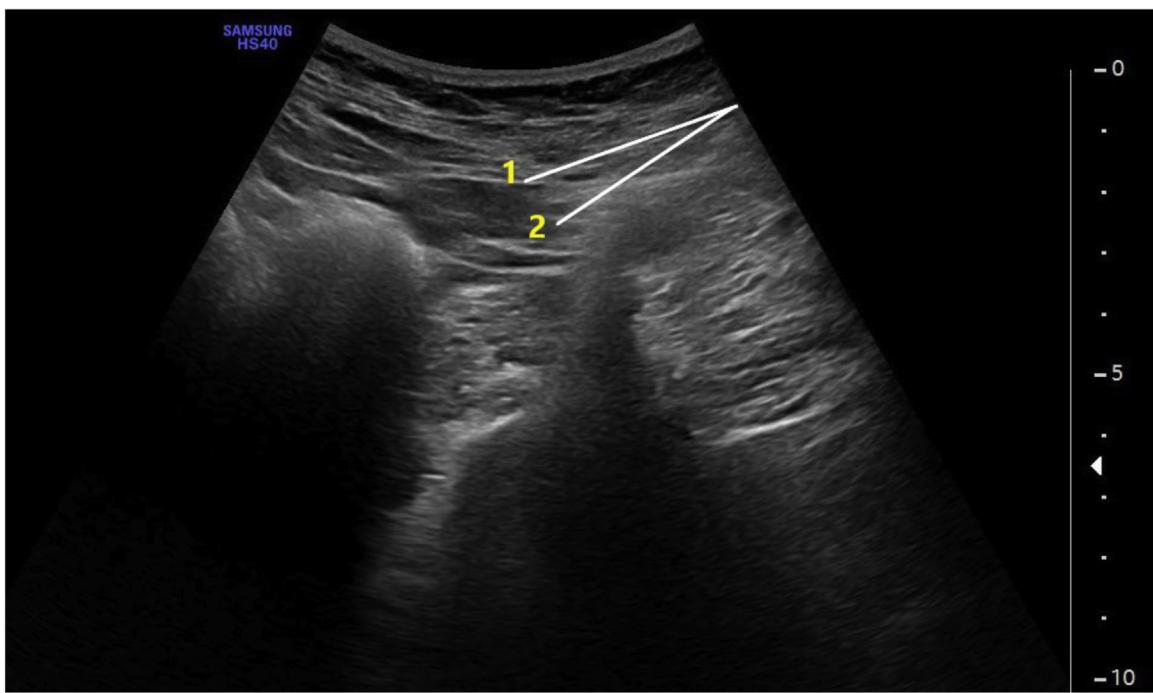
Ultrasound imaging of the quadratus lumbar muscle infiltration. (1) Intermediate layer of thoracolumbar fascia (posterior fascia quadratus lumbar muscle); (2) Intramuscular infiltration of the quadratus lumbar muscle.
